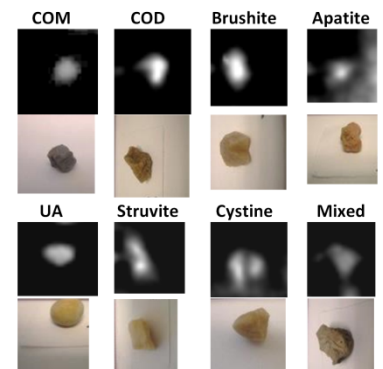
Different kidney stones imaged with MRI, and the actual stones.
